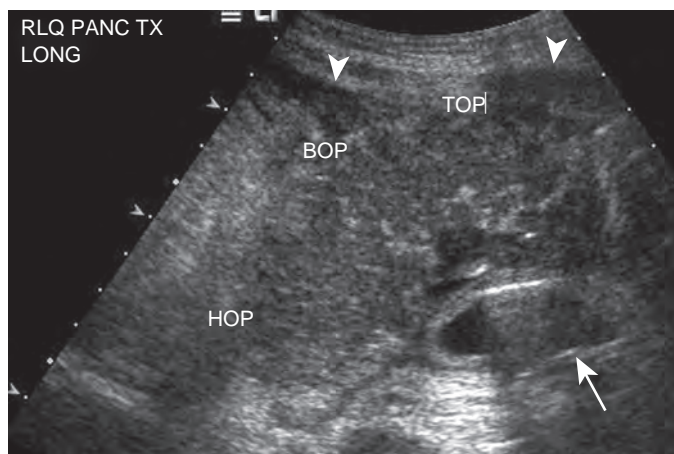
Postoperative pancreatitis after SPK transplantation in a 27-year-old woman. Longitudinal ultrasound image demonstrates an enlarged, hypoechoic transplant with surrounding fluid (arrowheads) and thickening of an adjacent bowel loop (arrow). HOP, head of pancreas; BOP, body of pancreas; TOP, tail of pancreas. (From Vandermeer F, Manning MA, Frazier A, et al: *Imaging of whole-organ pancreas transplants*. *RadioGraphics* 32:411–435, 2012.)
